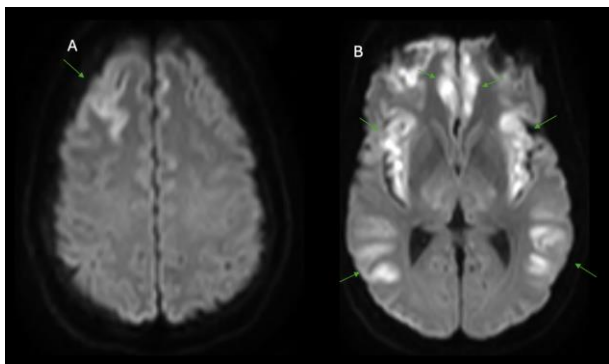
Acute hepatic encephalopathy with characteristic cortical involvement pattern. (A) Axial DWI demonstrates restricted diffusion in the right frontal cortex with notable sparing of the perirolandic region. (B) Bilateral symmetric diffusion restriction involving the insular and cingulate cortices along with temporal lobes, while characteristically sparing the occipital cortex. This distribution pattern of cytotoxic edema with perirolandic and occipital sparing is typical of acute hyperammonemic injury.
